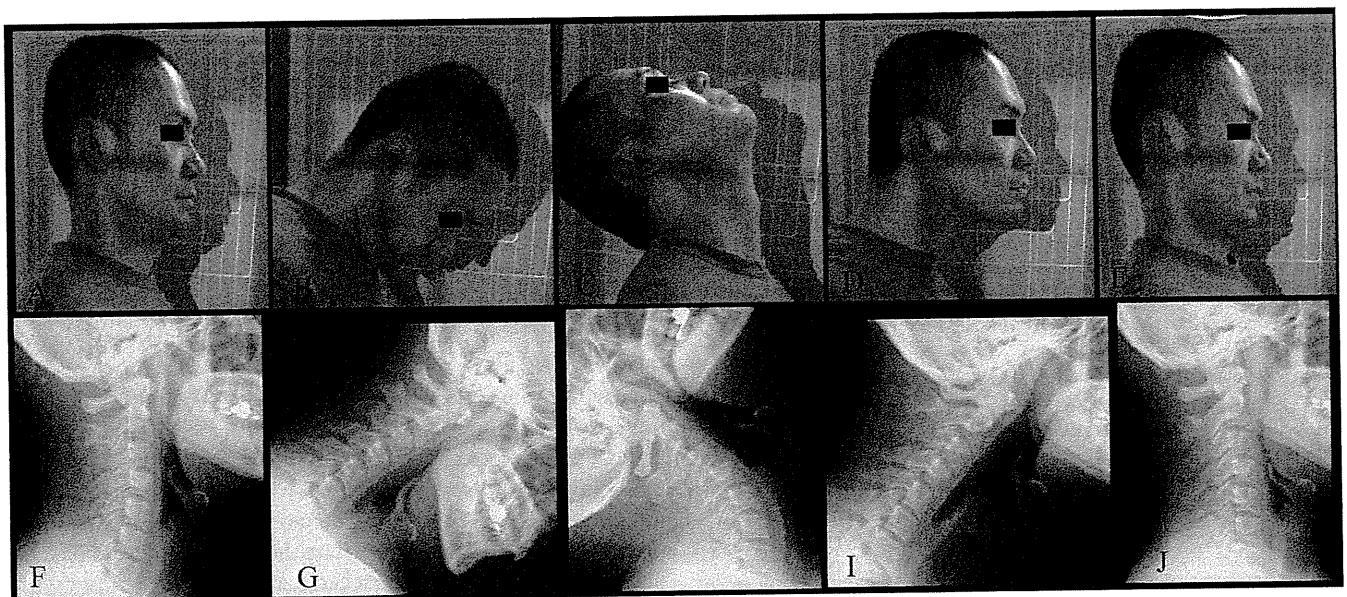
Five lateral cervical postures and radiographs in the neutral (A, F), flexion (B, G), extension (C, H), protrusion (D, I), and retraction (E, J) positions.
